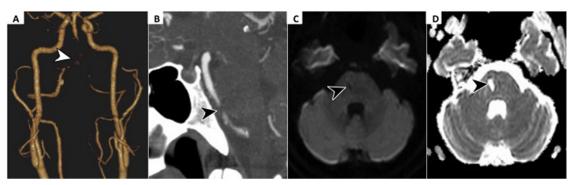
Neuroimaging 3 months after initiating enzyme replacement therapy. (A and B) CTA of head and neck depicting severe stenosis of the vertebrobasilar junction. (C) Diffusion-weighted MRI and (D) Apparent diffusion coefficient sequences demonstrates old right pontine stroke without new ischemic lesions. Abbreviations: CTA, computed tomographic angiography; MRI, magnetic resonance imaging.
